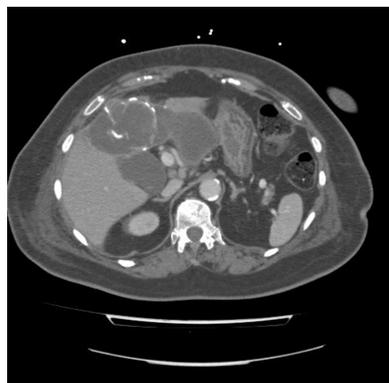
Abdominal computed tomography: Percutaneous drainage inside liver hydatid abscess.
